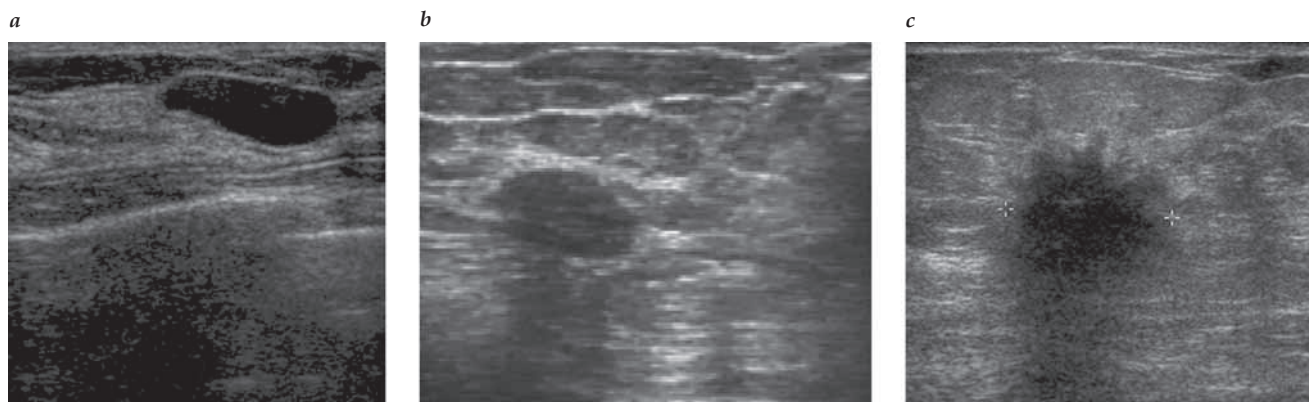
Breast ultrasonography. Shown are (a) a simple cyst that has smooth margins, is anechoic, and shows posterior enhancement; (b) a fibroadenoma that has smooth margins, is hypoechoic, and shows posterior shadowing; and (c) a mammary carcinoma that has irregular borders, is hypoechoic, and shows irregular posterior shadowing.
